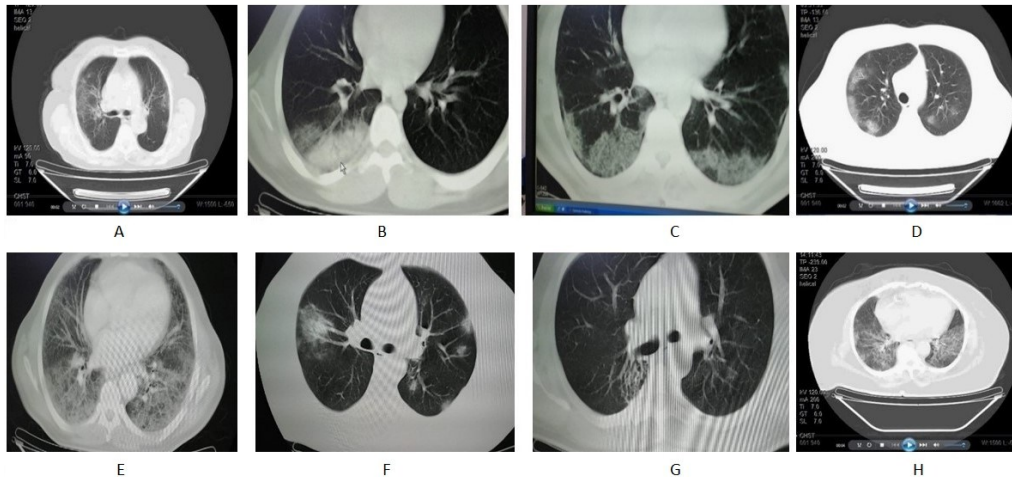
CT images of a COVID-19 patient. A) Bilateral multi lobar, subpleural, diffuse ground glass opacities in both lungs. B) Lesion, which was compatible with pneumonia, in the superior segment of lower lobe in the right lung. C) Ground glass opacities with multilobar, peripheral location in lower lobes of both lungs. D) Ground glass opacities with multilobar, peripheral location in both lungs. E) Bilateral, interstitial pattern and ground glass opacities with diffuse distribution in all segments of all lobes in both lungs. F) Reticular pattern and ground glass opacities with multilobar, subpleural location in both lungs. G) Focal ground glass opacities with multilobar, peripheral location in both lungs. "Honeycomb view" in the superior segment of the lower lobe of the right lung. H) Diffuse, multifocal, ground glass opacities and reticular pattern in both lungs.
